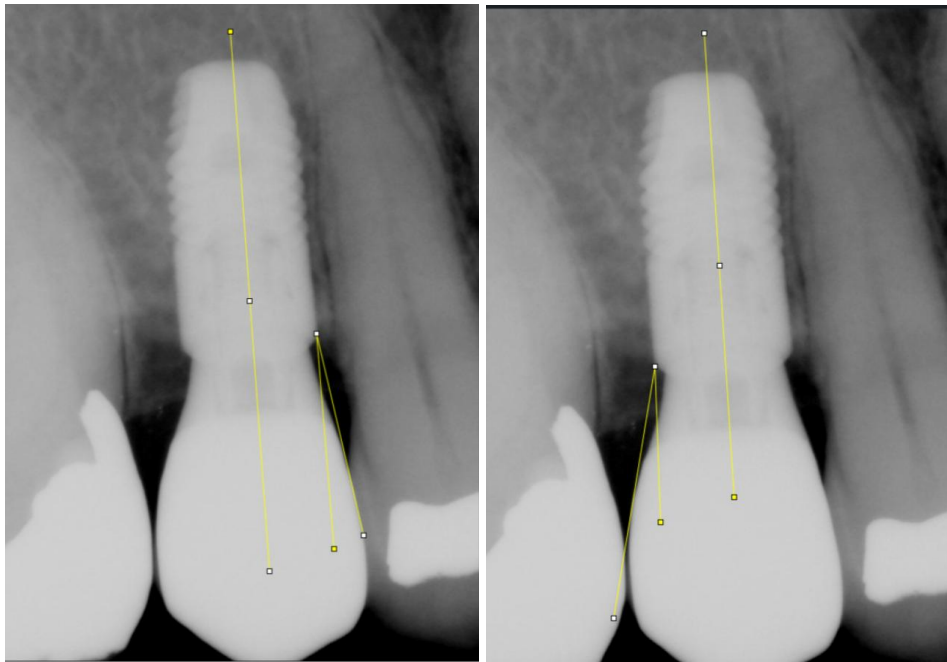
The radiograph of the emergence angle and interproximal profile being calculated. This calculation was performed on the mesial and distal aspect of the #15 implant. The angle calculated in this case was 9.1° and 12.5°, respectively. Based on this radiograph, given the restorative material being deficient to the line drawn from the implant platform to the point just apical to the interproximal contact, this interproximal profile was classified as concave.
